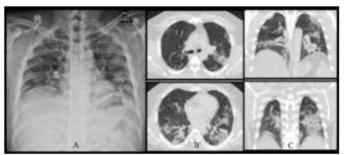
A. A chest X-ray and axial (B), coornal (C) CT picture in a 37-year-male moderate common type patient (5 days from symptom onset to chest X-ray and CT scan) reveals multiple GGO in both lungs.
